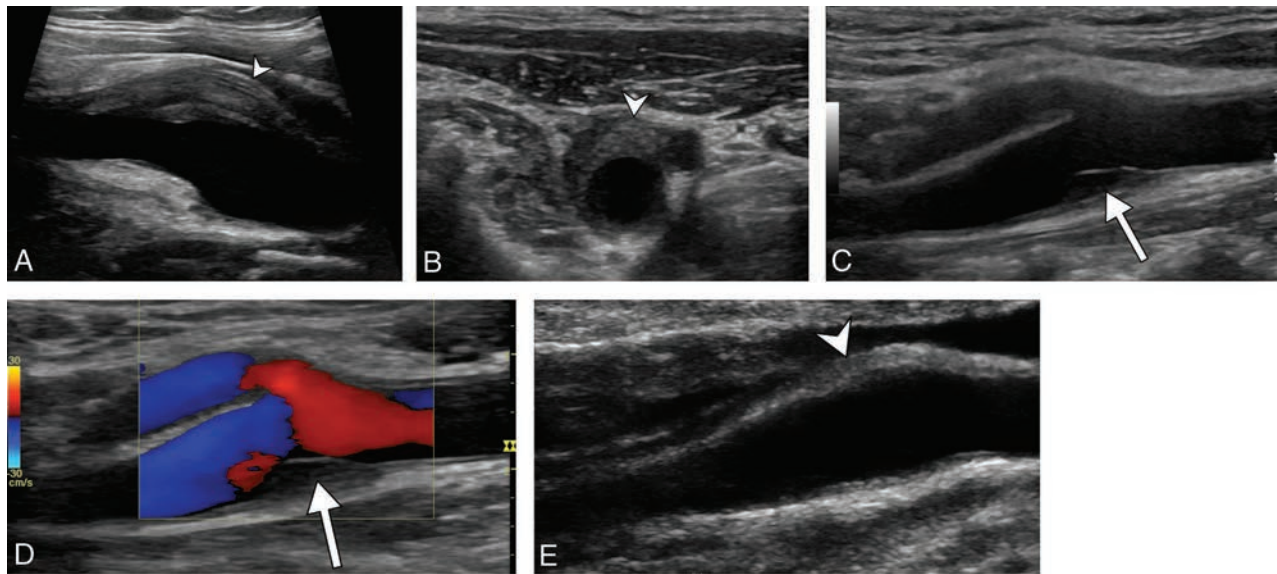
Diagnostic ultrasonography (A–D) shows an eccentric perivascular infiltration (arrowhead) at the level of bifurcation, with a soft intimal plaque (arrow) and a mild lumen narrowing without a hemodynamic change in Doppler mode. Follow-up ultrasonography (E) shows a marked decrease in the perivascular infiltration (arrowhead) and complete disappearance of the soft intimal plaque.
